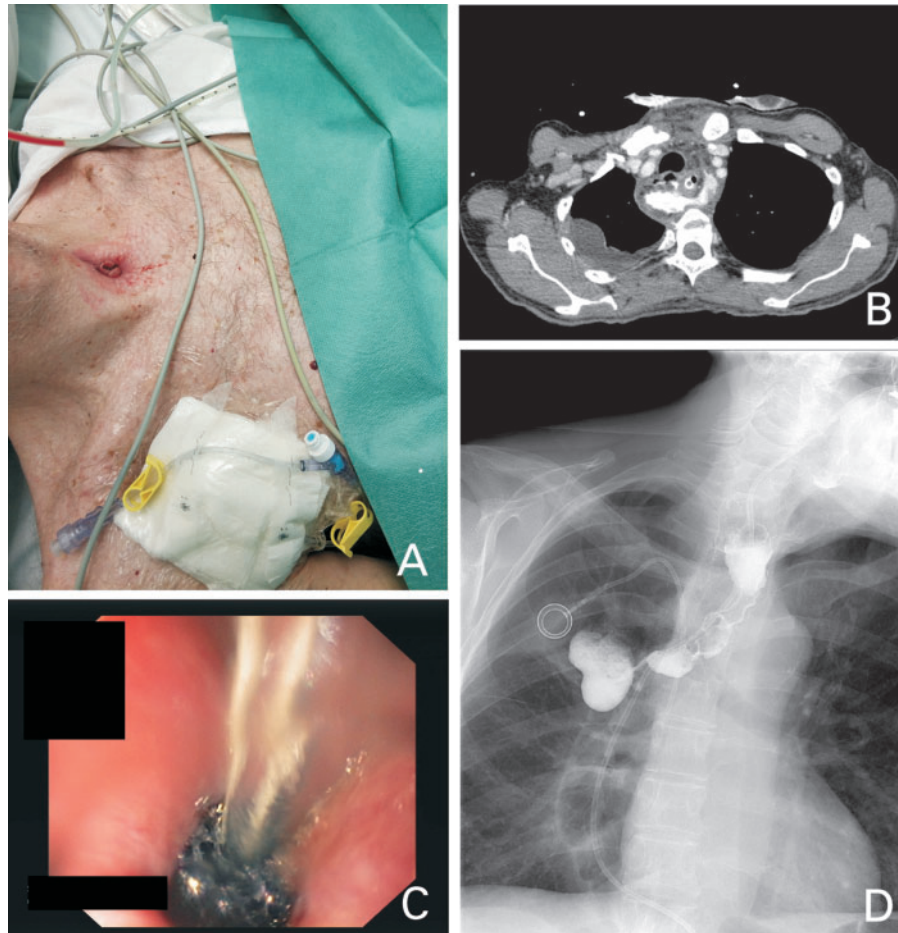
A cervical anastomotic leakage cured with endoscopic vacuum device. (A) Cervical oesophagoileostomy fistula after total oesophagectomy with right-colon interposition. (B) Thoracic CT scan showing mediastinal collection with extra-luminal contrast leakage. (C) Endoscopic vacuum (E-Vac) device placement. (D) Post E-Vac therapy swallow test showing correct downstream flow through the cervical anastomosis, without leakage or other complications.
